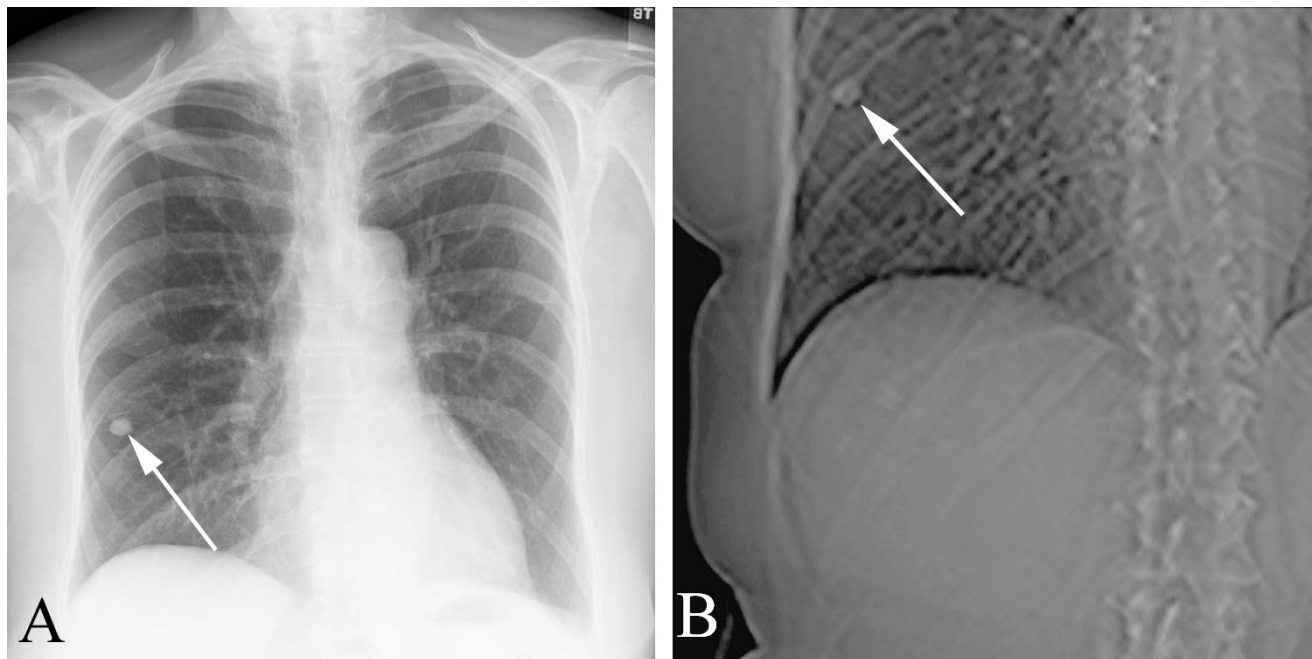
Chronic granulomatous disease in a 72 year old woman with an incidentally discovered pulmonary nodule. A. Chest radiograph of a 72 year old woman with leukocytosis following a total knee replacement shows a right pulmonary nodule (arrow). B. The patient had no old chest radiographs, but the scout film from a prior abdominal CT showed the nodule unchanged from three years earlier (arrow).
